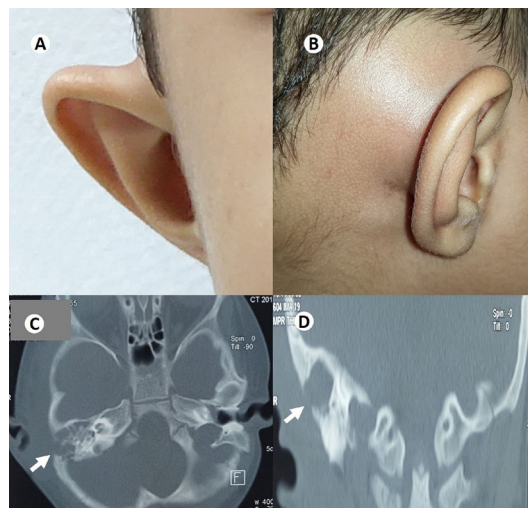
Clinical image depicting the pinna position (A), fluctuant postaural swelling (B). Axial and coronal high-resolution CT scans of the temporal bones showing complete opacification of the right mastoid air cells with erosion of mastoid cortex (indicated by arrow in C and D).
